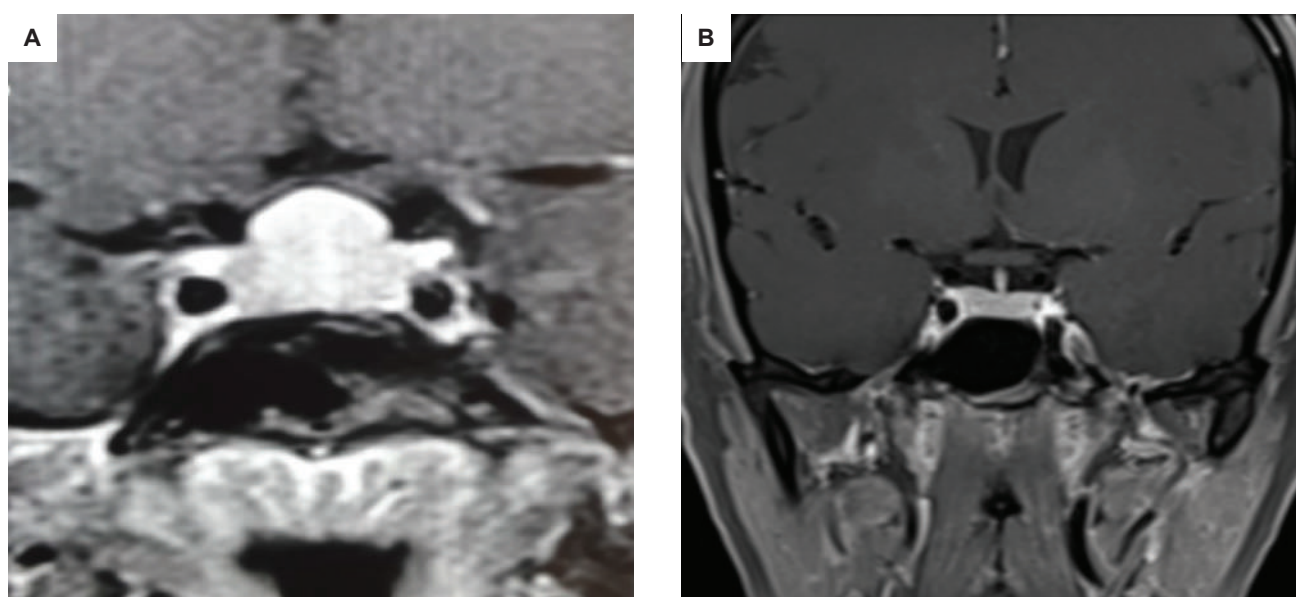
(A) Coronal post contrast T1-weighted image showing dome-shaped superior convexity of the pituitary prior to starting levothyroxine therapy. (B) Post coronal T1-weighted image showing post-levothyroxine therapy depicting total resolution of the thyrotroph hyperplasia and obliteration of the “dome.”
